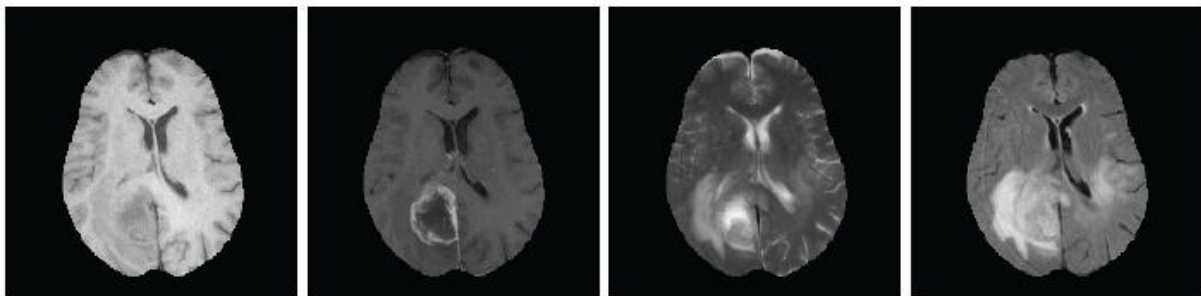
Axial slice of four MRI modalities of one patient. From left to right: T1, T1c, T2, T2flair
